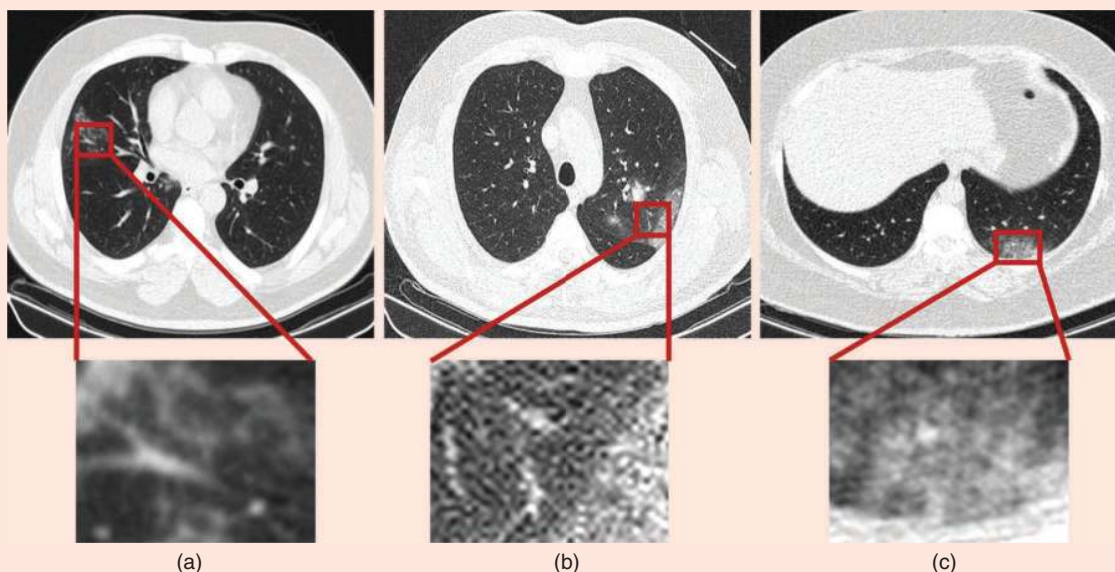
Acquired CT images with three different dose levels for three COVID-19 patients: (a) standard, (b) low, and (c) ultralow doses [82].
